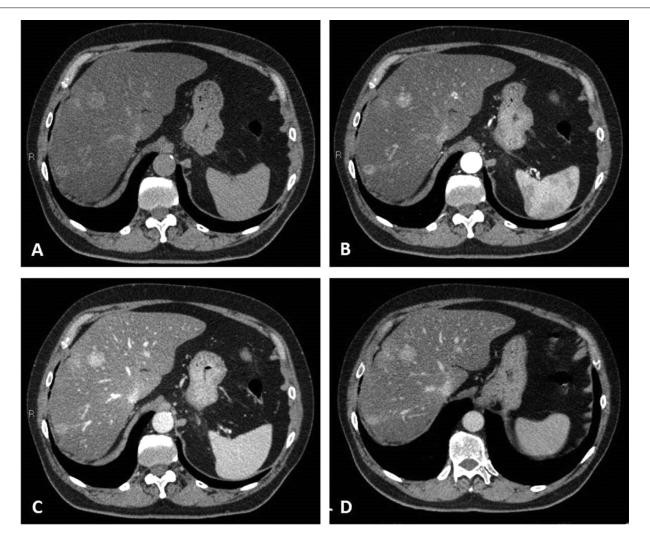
Computed tomography confirmed the presence of 2 new hepatic nodules in segment VIII and VII slightly hyperdense on unenhanced CT (A), characterized by intense and homogeneous contrast enhancement in the arterial phase (B) with persistent enhancement on venous (C) and delayed phase (D), suspected for metastases.
